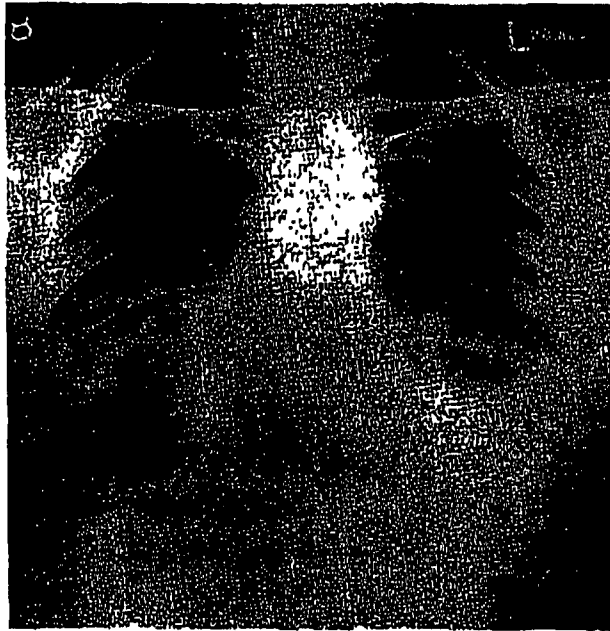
Male aged 49 years (1953). 1926–38, asbestos millboard cutter; 1938–43, timekeeper and gatekeeper; 1943 *et seq.*, despatch clerk. Typical radiographic appearances of advanced asbestosis; clubbing of fingers (see Fig. 13). At present working regularly. (By courtesy of Dr. H. Wyers.)
